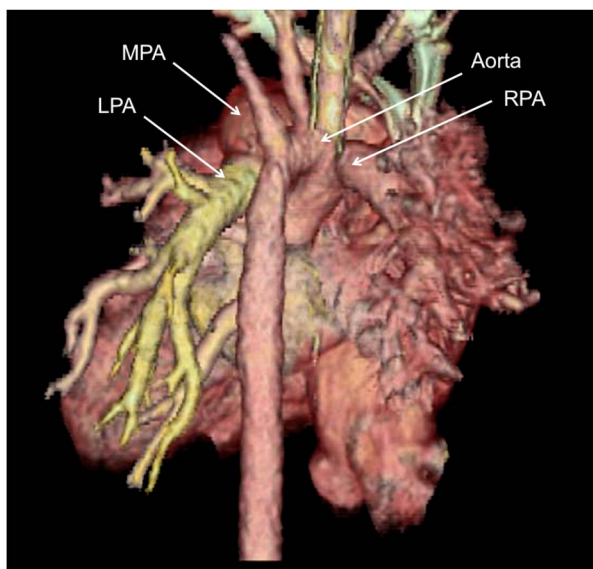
Three-dimensional reconstruction of chest CT angiogram, with a posterior view demonstrating anomalous origin of the right pulmonary artery from the ascending aorta and dilated left pulmonary artery arising from the main pulmonary artery. LPA = left pulmonary artery; MPA = main pulmonary artery; RPA = right pulmonary artery.
